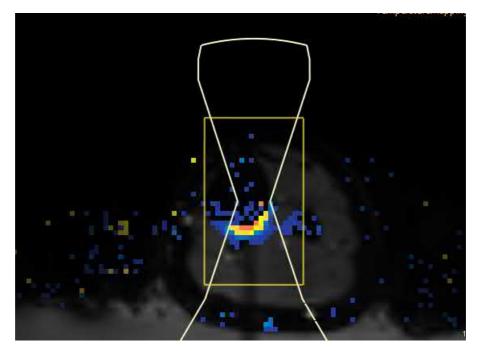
Example of artifactual heating outside the ultrasound beam path.
